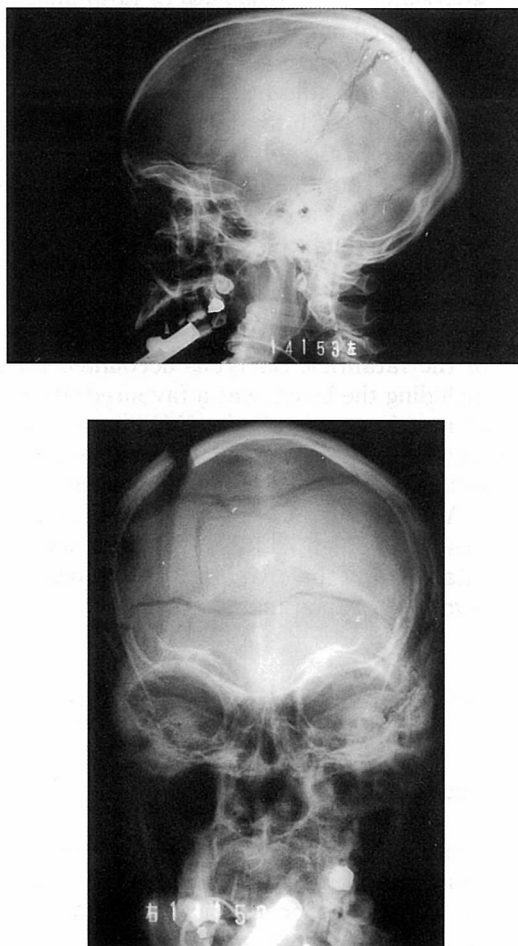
X-ray films of the skull showed the bone fracture of the right parietal bone, and radiopaque materials.
